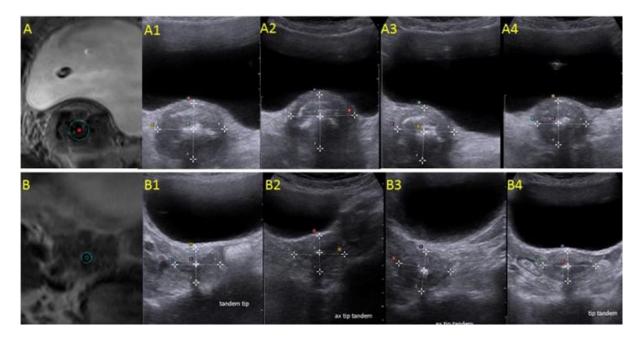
MRI and ultrasound verification images
